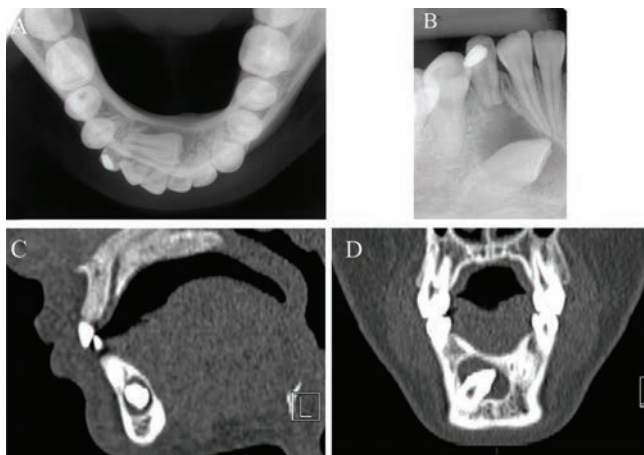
A) Occlusal radiograph. B) Periapical radiograph. C) Computed tomography sagittal scan showing a large hypodense lesion with intact lingual and buccal cortices. D) Computed tomography coronal scan.
